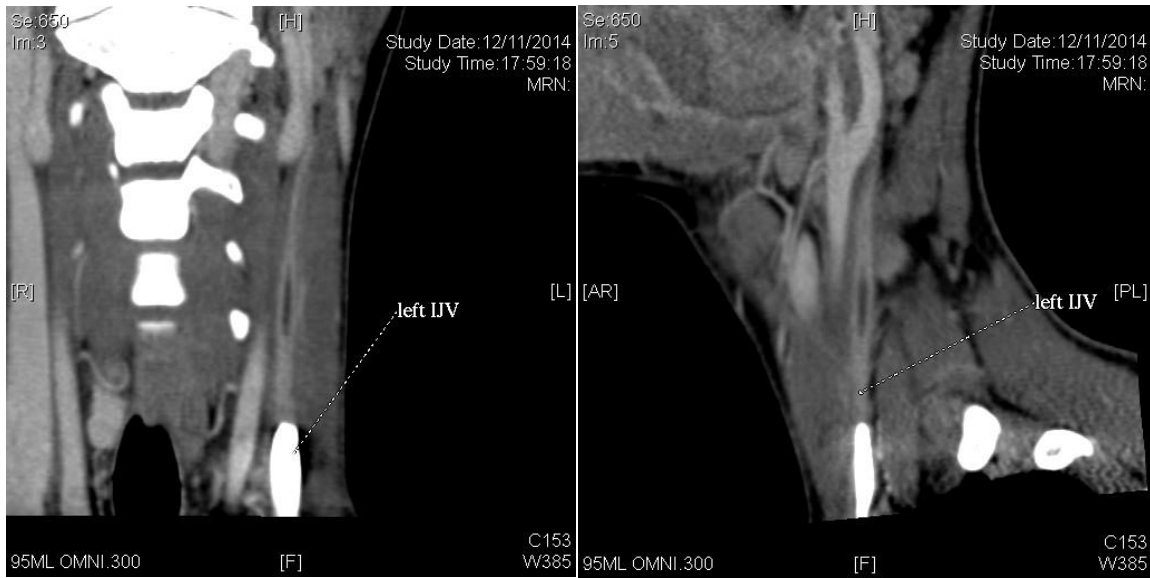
CT venogram in an oblique sagittal view showed presence of filling defect in the mid left internal jugular vein, confirming jugular venous thrombosis.
